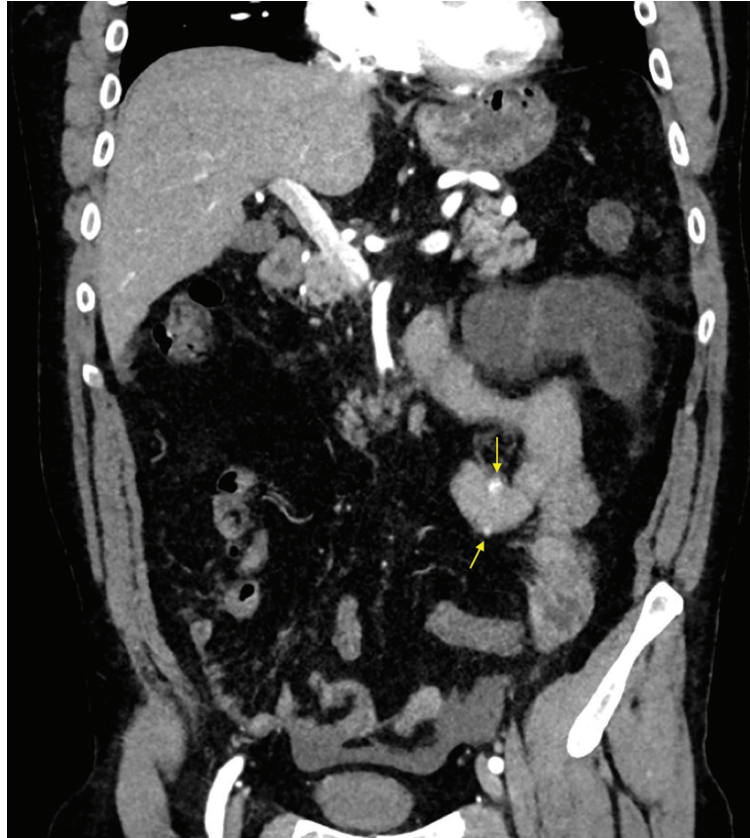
Contrast-enhanced abdominal CT scan, in the coronal plane, with arterial phase. The CT scan showed two lesions in the wall of a jejunal loop (arrows) with exophytic growth and intense enhancement, indicative of GIST.
